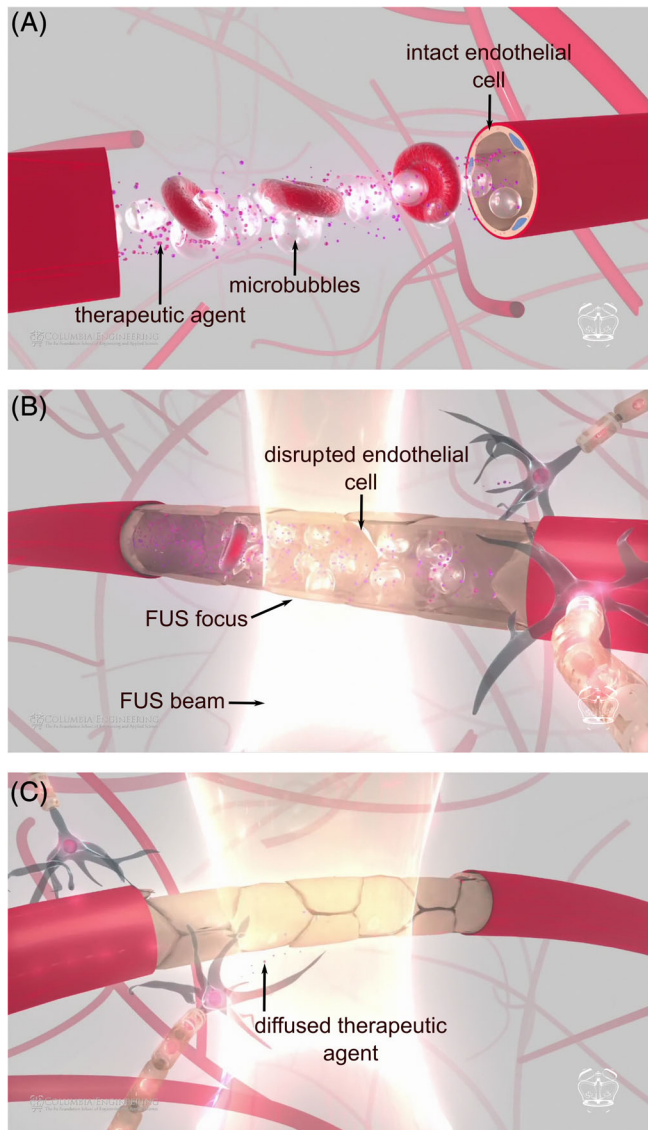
Mechanism of blood–brain barrier opening disruption. (A) The microbubbles (white) and the therapeutic agent (purple) follow the circulation after intravenous injection. (B) The microbubbles oscillate when reaching the focus of the beam that exerts mechanical forces to the endothelial cells and loosens the tight junctions. (C) The therapeutic agent diffuses through the disrupted barrier into the brain parenchyma. FUS, focused ultrasound. [Color figure can be viewed at wileyonlinelibrary.com]
